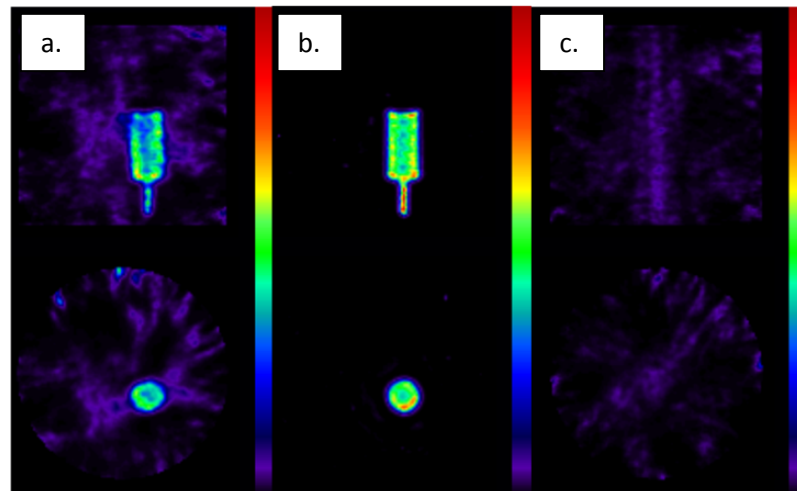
Panel a, b, and c show representative slices of SPECT images of the $^{99m}\text{Tc} + ^{18}\text{F}$, $^{99m}\text{Tc} + \text{H}_2\text{O}$, and $^{18}\text{F} + \text{H}_2\text{O}$ syringe combination respectively. Visual inspection shows the degradation in image quality when ^{18}F is present in the scans.
